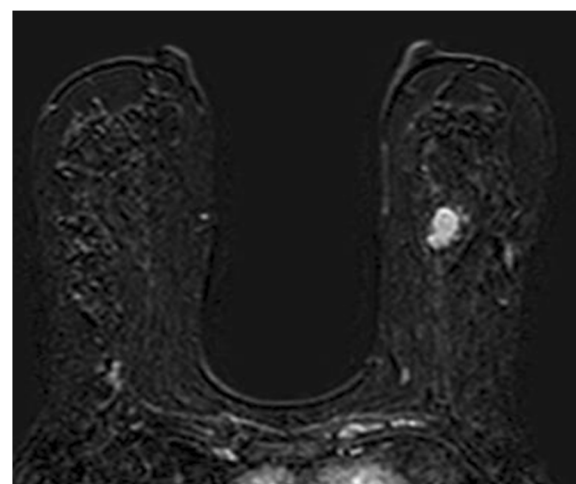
Axial early subtraction MR image shows heterogeneously enhancing mass with speculated borders seen in the left breast. The nipple morphology appears normal and symmetrical on both sides, no tumor nipple enhancement, no periareolar skin thickening with tumor nipple distance of about 5.2 cm, and no abnormal nipple enhancement. Pathological diagnosis revealed grade II IDC with free NAC. ER, positive; PR, negative; Her 2, positive and high Ki67
